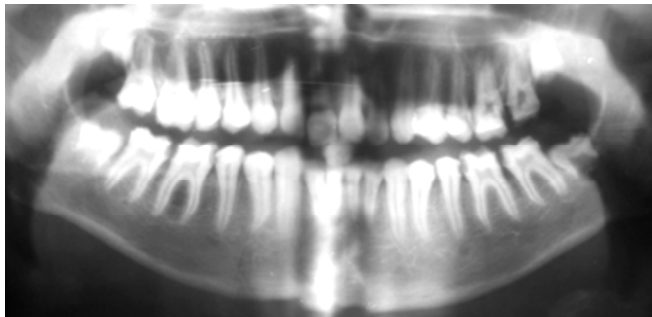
Radiographic appearance of teeth affected by amelogenesis imperfecta
